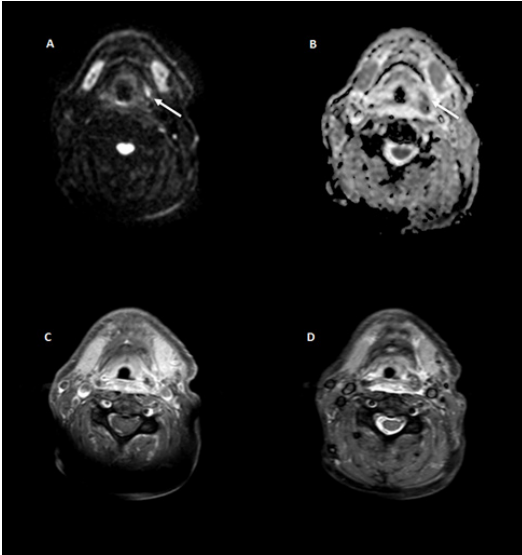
Axial MR images with different contrasts of the case with the lowest interobserver agreement (case 5). Clinical information available to the observers included the following details: *74 year old female with T4aN2bM0 carcinoma of the left tonsillar region extending to the lateral pharyngeal wall treated with radiotherapy. Now suspected of recurrence.* The white arrow indicates a region with low apparent diffusion indicative for diffusion restriction which is suspected for malignancy. However, for this patient biopsy did not show carcinoma and no recurrence occurred during follow up. The diffusion restriction could be based on postradiation effects. It must be noted that the location of the diffusion restriction does not match the localization of the primary tumor. This is a possible explanation why five observers scored this case as a local control despite the restricted diffusion. A: Diffusion weighted $b = 1000 \text{ s/mm}^2$, B: ADC, C: T1w SPIR + Gd contrast, D: PD SPIR.
